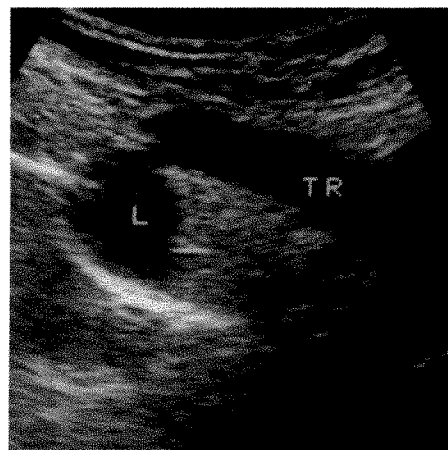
Tumor recurrence in a 28-year-old woman with Hodgkin lymphoma. This patient was treated for Hodgkin lymphoma 2 years before. Suprasternal sonogram shows a hypoechoic lymph node (L) with a diameter of 2.0 cm in right paratracheal region. TR = brachiocephalic trunk.
